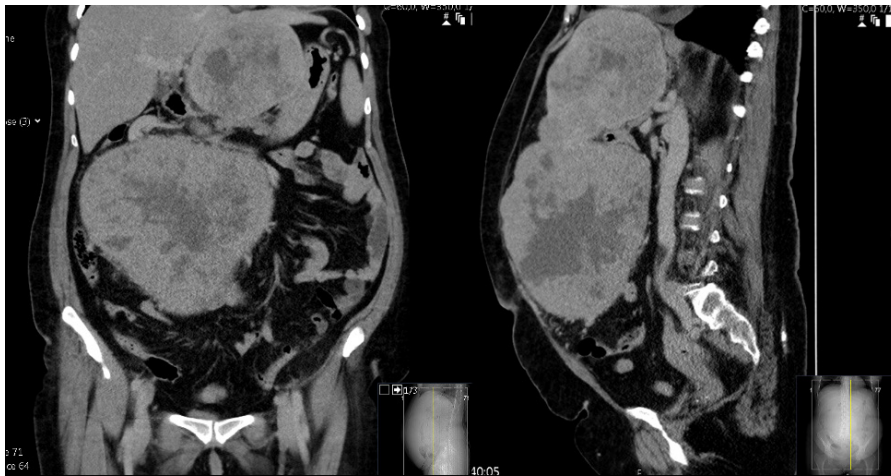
Computed tomography images with evidence of multiple hepatic and peritoneal tumors.
